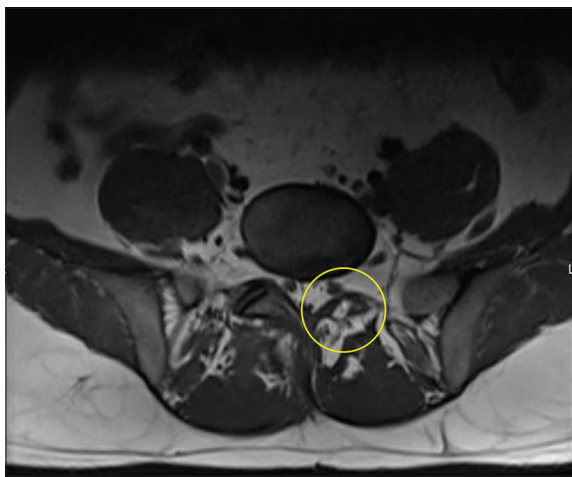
On axial spine MRI, the left inferior articular process of L5 is absent, with the superior articular process of the S1 markedly hypoplastic.
